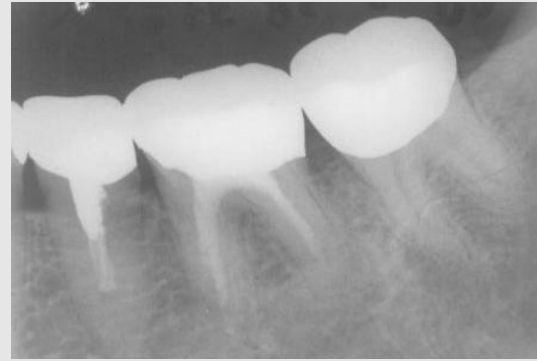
Success case: post-op periapical view.
